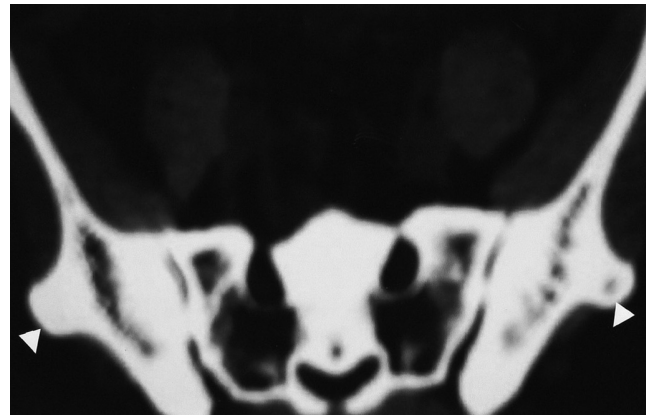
Pelvis CT scan shows the bilateral iliac horns (arrow heads), bony projection posterolaterally.
